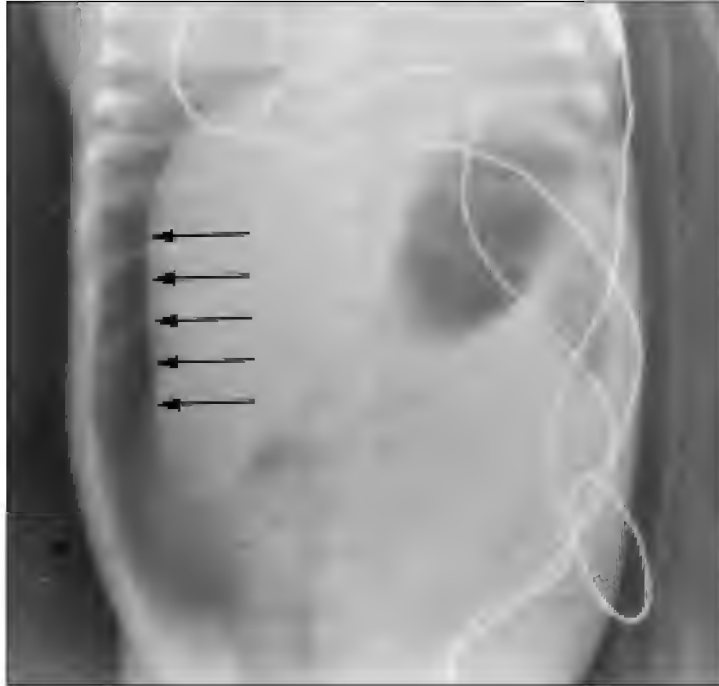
Premature neonate (800 grams) with massive free air from necrotizing enterocolitis. Arrows outline hepatic edge on decubitus radiograph.
